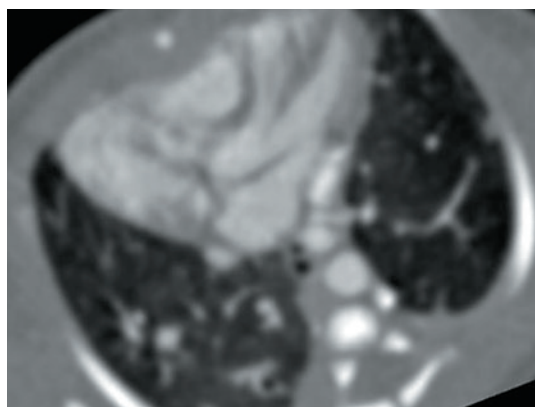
Horseshoe lung. A CT scan (axial view; lung window) shows an isthmus of the pulmonary tissue between the left and right lungs located to the front of the aorta and behind the left atrium and containing bronchi and vessels
